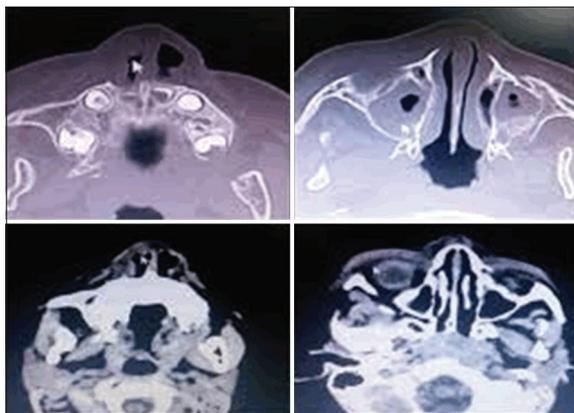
Computed tomography film showing nasal furuncle with preseptal cellulitis and maxillary sinusitis
